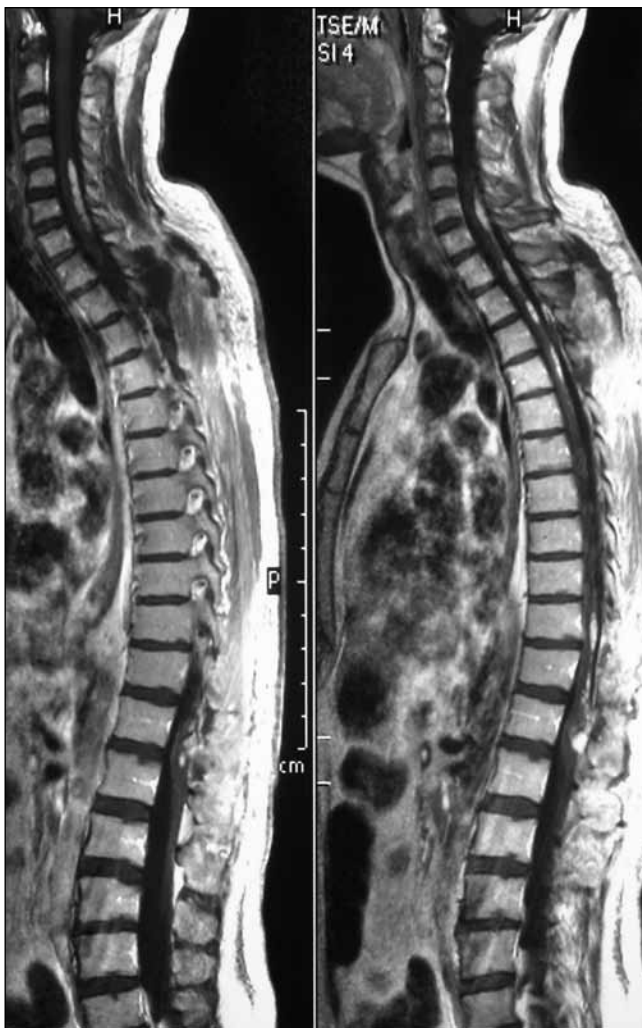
Early post-operative gadolinium-enhanced sagittal T-1 MR images showed resolution of the syrinx cavity and fatty contents and post-operative enhancement in the removed area of the conus medullaris mass lesion.
